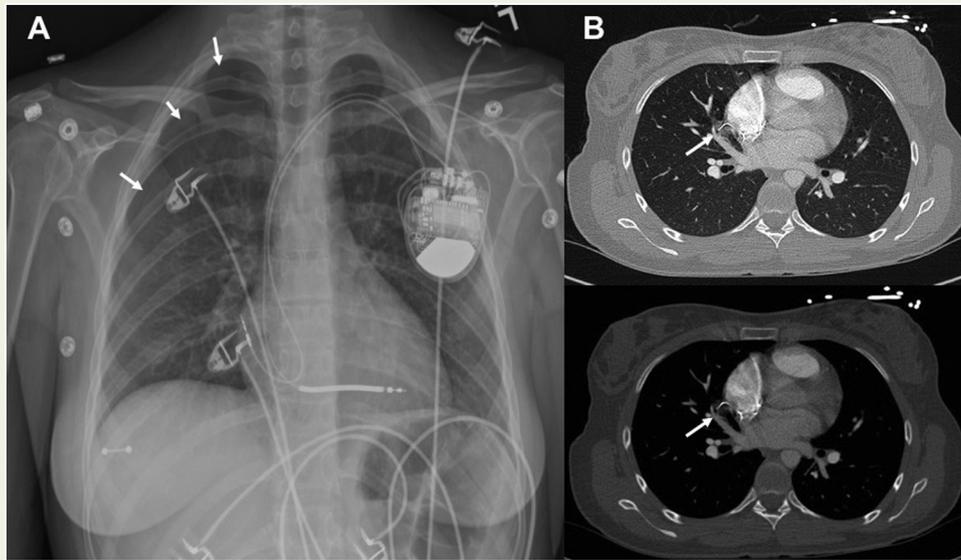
Anteroposterior view of the chest x-ray following ICD placement (A) and Helical computed tomography scan of the chest with intravenous contrast (B-C). A moderate right apical pneumothorax is observed. New left-sided ICD placed with pulse generator in the anterior chest wall and transvenous leads extending via the left subclavian vein and superior vena cava into the right atrium and right ventricle. (B-C) Thin-slice axial images in the lung window at the level of the pulmonary veins (B) and in bone window (C). Focal, minimally consolidative and ground-glass opacity in the medial right middle lobe, in close proximity to the right atrial ICD wire. Accurate delineation of the atrial lead tip is limited by motion and metal artefact.
